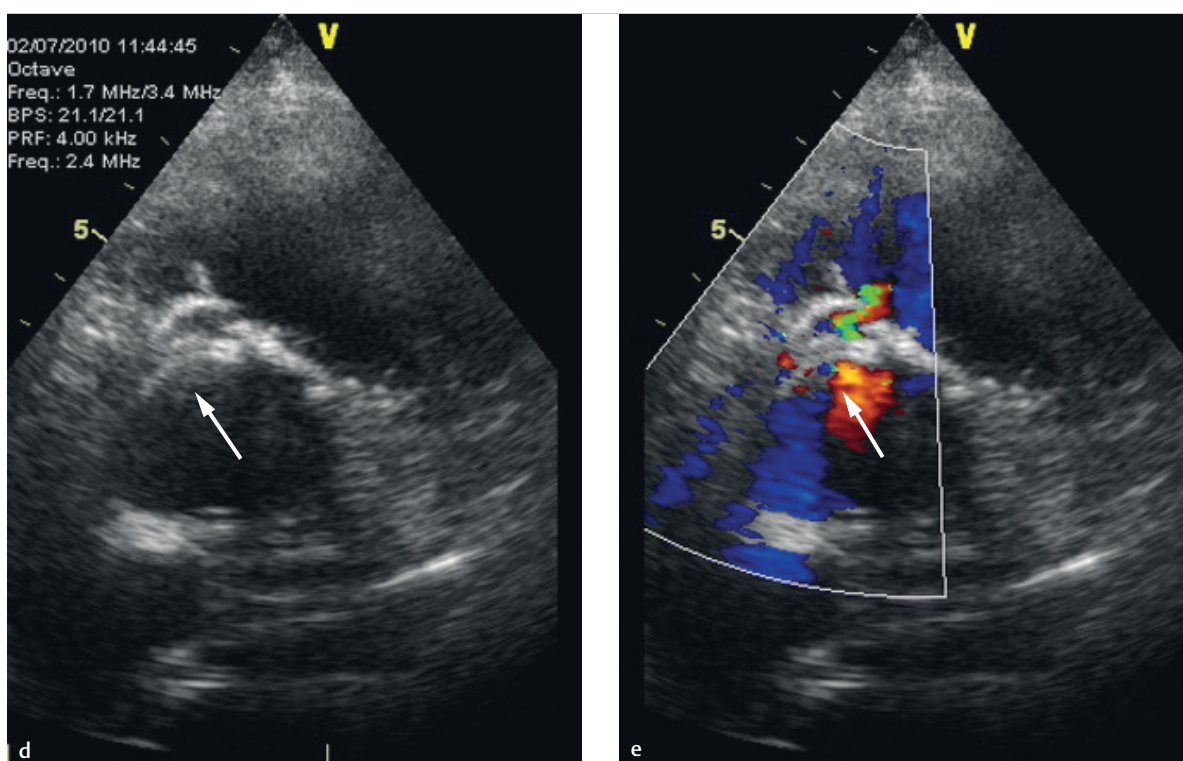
(Continued) Combination with ultrasound and angiography. Echocardiographic and angiographic depiction of a VSD closure.
